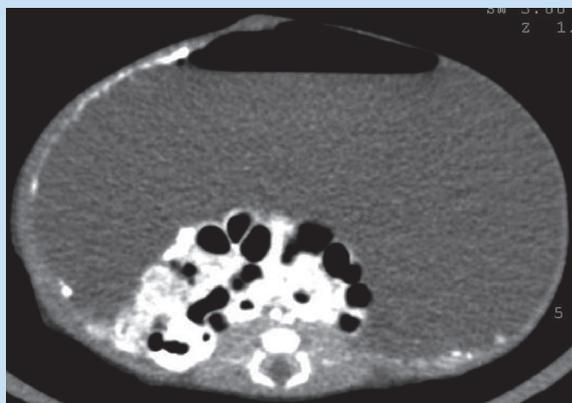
Axial CT revealing anterior intraperitoneal free air. The meconium ascites causes posterior displacement of bowel loops. Note the peripheral calcifications.
